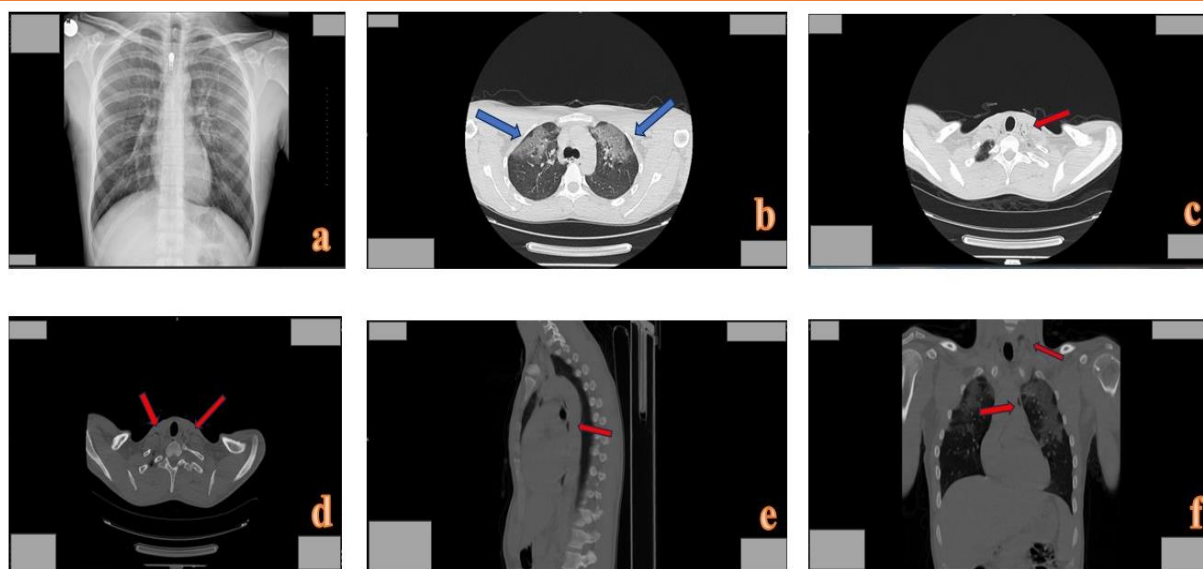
Radiological imaging obtained at emergency department presentation. (a) Posteroanterior (PA) chest radiography. (b) Axial chest CT (lung window) demonstrating bilateral upper-lobe parenchymal opacities consistent with pneumonia (blue arrows). (c–d) Axial CT images showing cervical soft-tissue air consistent with subcutaneous emphysema (red arrows). (e) Sagittal and (f) coronal CT reconstructions demonstrating mediastinal and cervical soft-tissue air consistent with pneumomediastinum and subcutaneous emphysema (red arrows)
